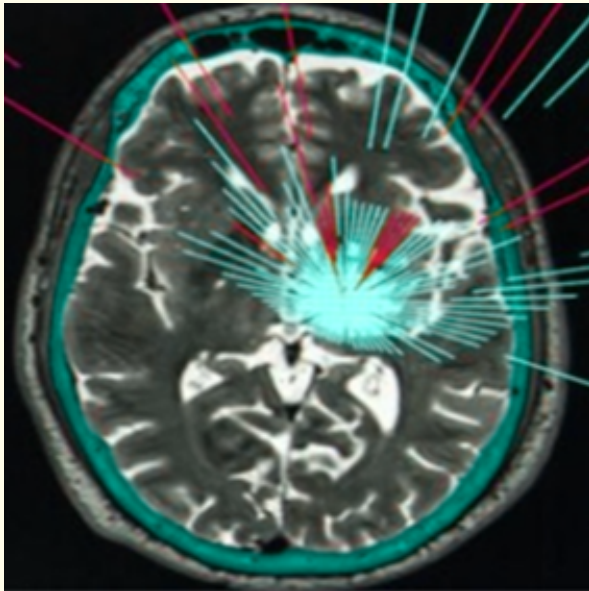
Ultrasound beams are displayed.*
